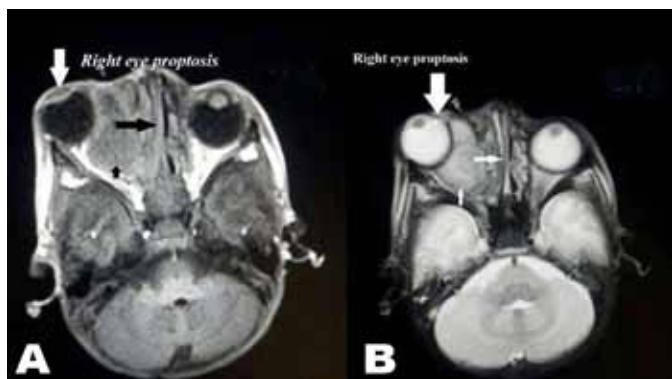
(A) Magnetic resonance imaging T1-weighted (axial image) scan of orbit and brain showing right eye proptosis with opacification of the right maxillary sinus (big black arrow) and a thick walled collection with rim enhancement extending from the right maxilla along the nasal, ethmoid sinuses to the medial wall of orbit, intraorbital extraconal mass (small arrow). Brain parenchyma and other structures is normal, (B) Magnetic resonance imaging T2-weighted (axial image) of orbit including brain showing similar findings (arrows).
